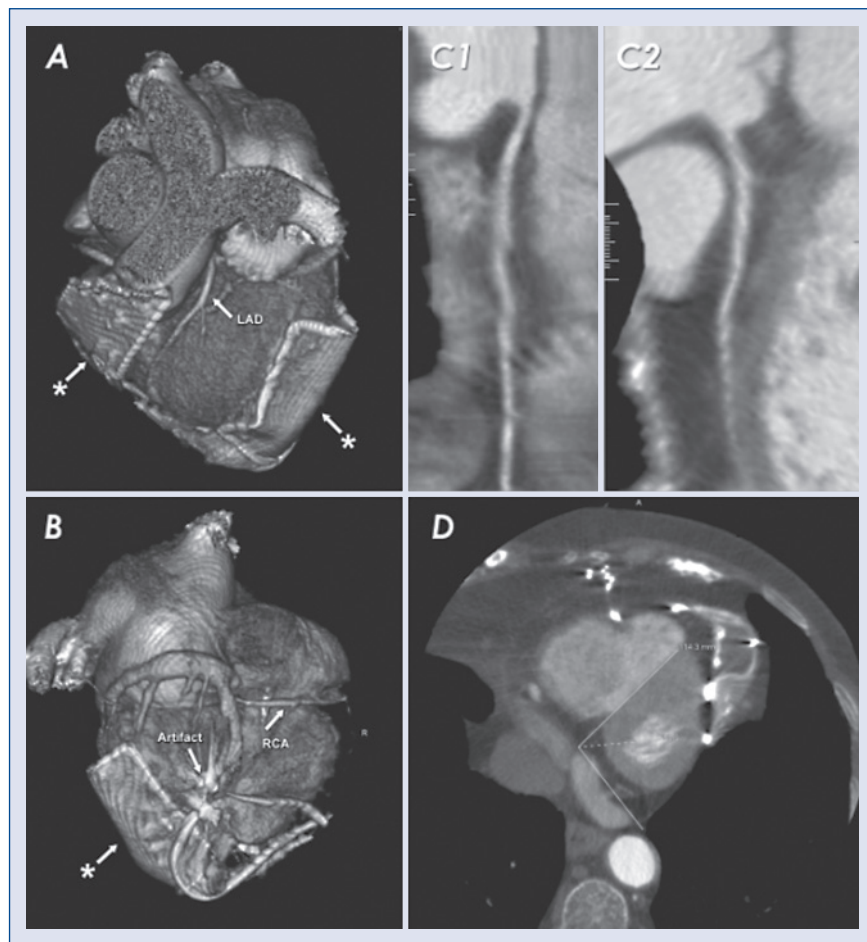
Multi-slice computed tomography (MSCT) images of patient with coexistence of transvenous (active) and epicardial (not active) leads; A, B. Three-dimensional images of the heart; *visible patch electrodes; C1, C2. Diagnostic visualization of the coronaries (LAD — left anterior descending artery, RCA — right coronary artery) despite the presence of both types of lead; D. Multi planar reformatted reconstruction with visible artifacts from the leads.
